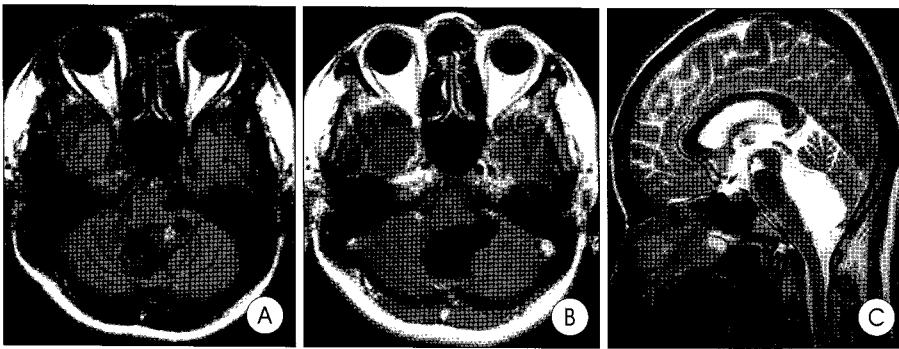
FLAIR (A), Gd-enhanced T1-weighted axial (B) and T2-weighted sagittal (C) images on admission: The epidermoid cyst occupies the fourth ventricle in which it grows and compresses the surrounding cerebellar hemispheres. It shows hypointensity without definite enhancing rim on T1-weighted, hyperintensity on T2-weighted and heterogenous signal intensity, between cerebrospinal fluid and the brain parenchyme on FLAIR image. The tumor also extends to the left-sided foramen of Luschka, and hydrocephalic change is noted.
